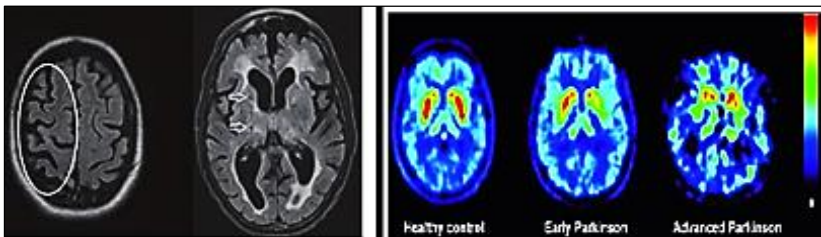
Parkinson's MRI brain & SPECT
